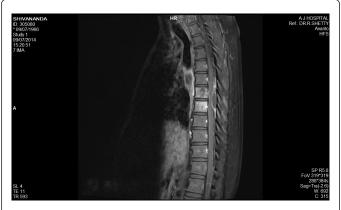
MRI dorsal spine (plain and contrast). Hetrogenously enhancing altered marrow signal at D6 and D7 vertebral bodies involving pedicle, pre and paravertebral collection at D4 to D8 levels, epidural collection at D6 and D7 levels compressing the theca and cord displacing it anteriorly.
